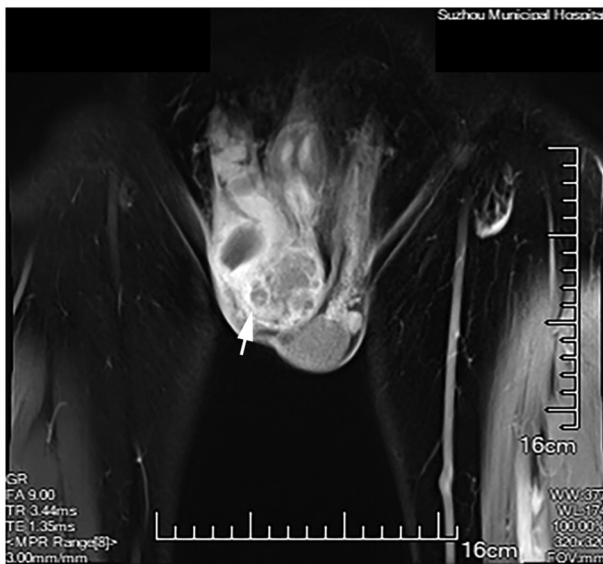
Contrast-enhanced magnetic resonance imaging of the testes demonstrates a right epididymal lesion with associated testicular compression.
